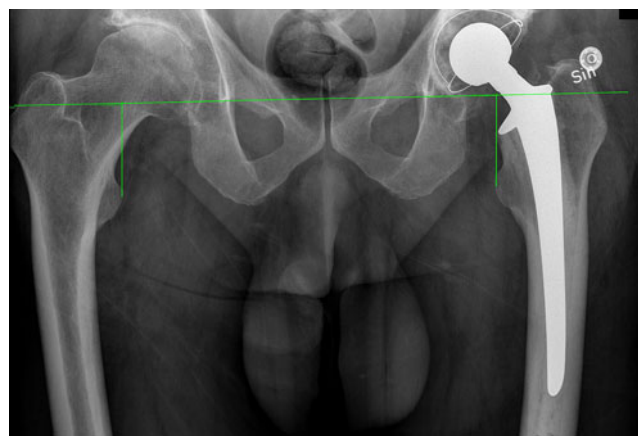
Radiographic measurement method. The LLD was defined as the difference in perpendicular distance in millimeters between a line passing through the lower edge of the teardrop points to the corresponding tip of the lesser trochanter
